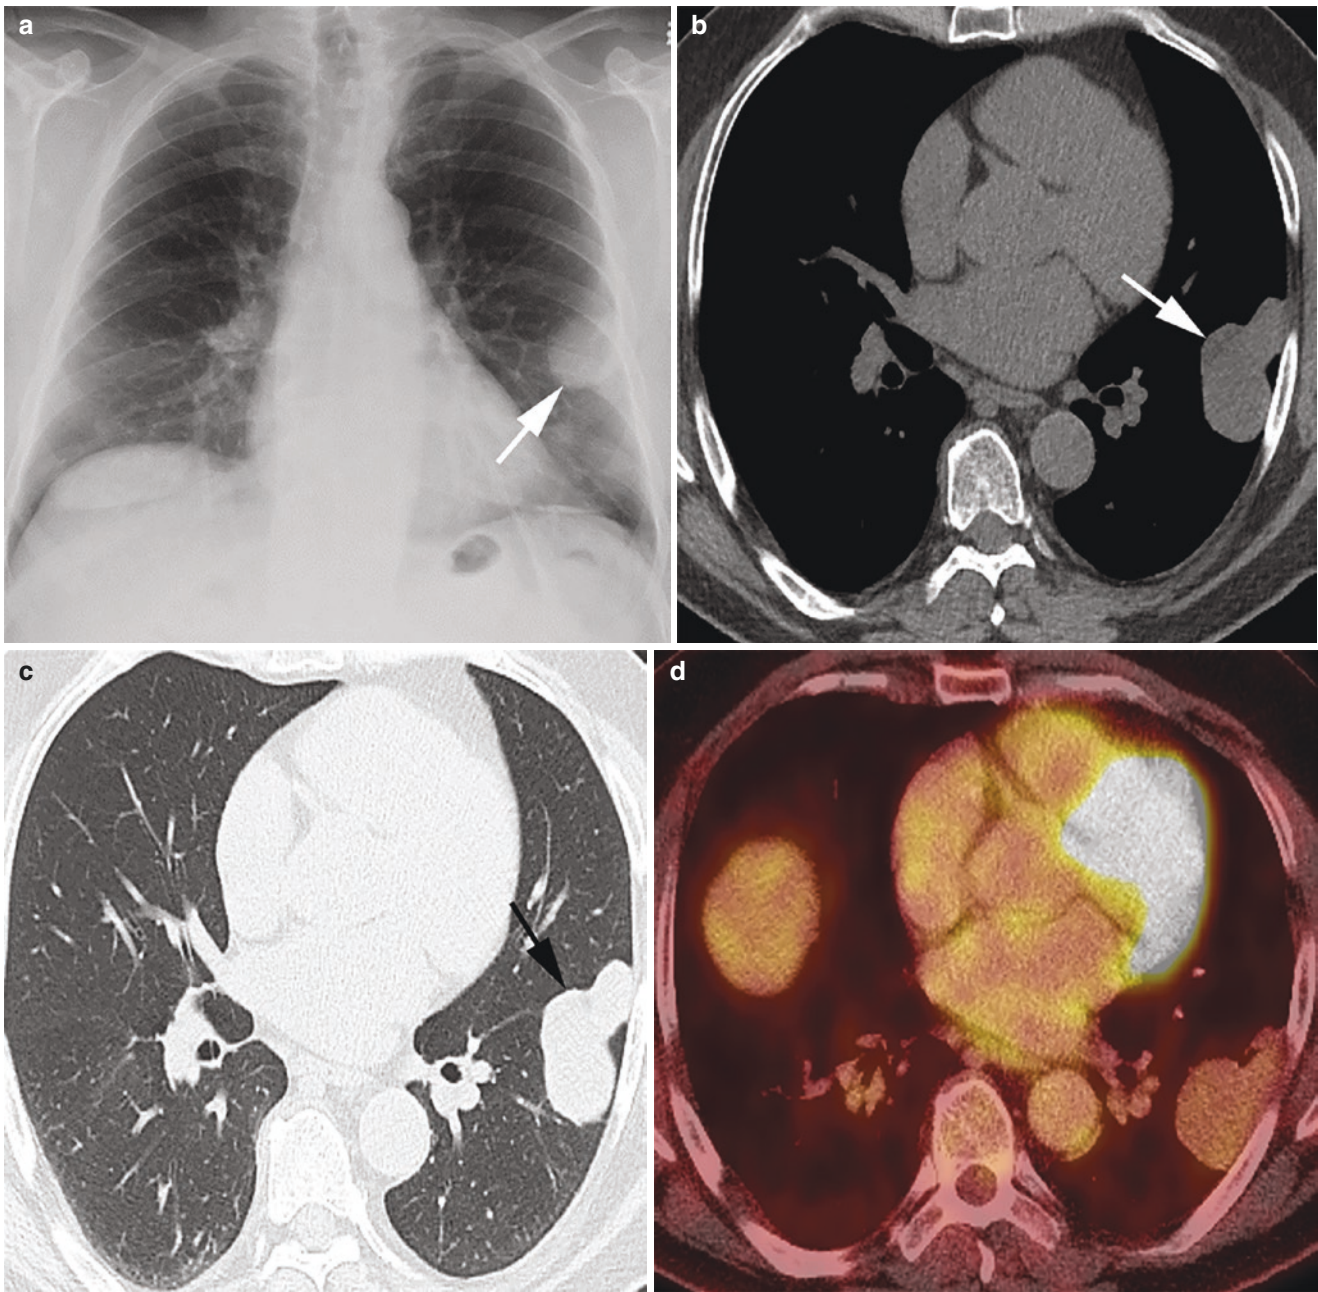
(a) Frontal chest radiograph shows well-defined mass in the left lower hemithorax abutting the lateral pleura (arrow), (b, c) axial CT in soft tissue and lung windows show homogeneous soft tissue mass
